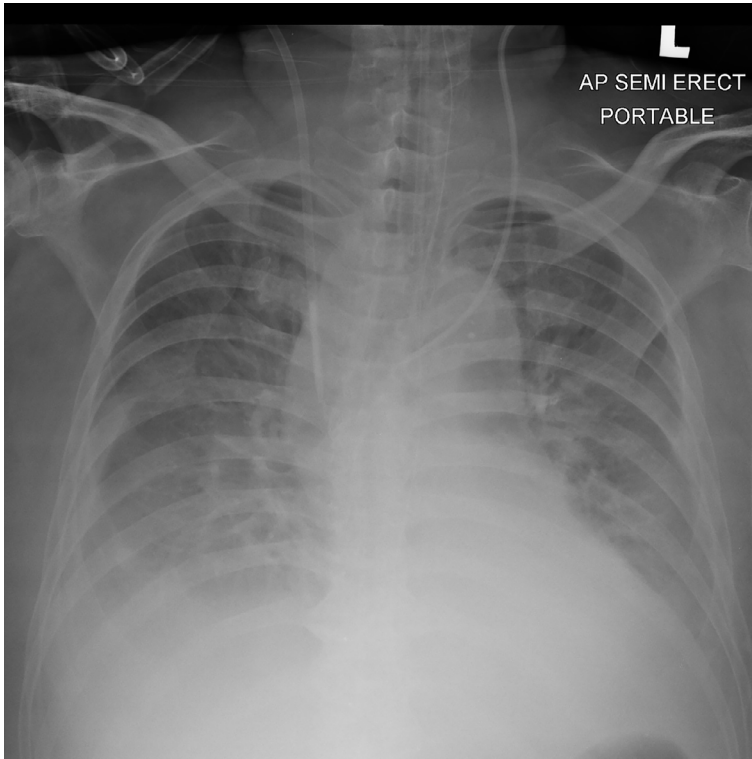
AP chest X-ray taken in semierect position on day 4 post-left internal jugular vein (IJV) central venous catheter (CVC) insertion and immediately post-right IJV double lumen catheter insertion. Greater bilateral pleural effusion is seen on the right side than in the left side. The left CVC tip was at the left innominate vein. The right double lumen tip was in the lower third of the superior vena cava.
